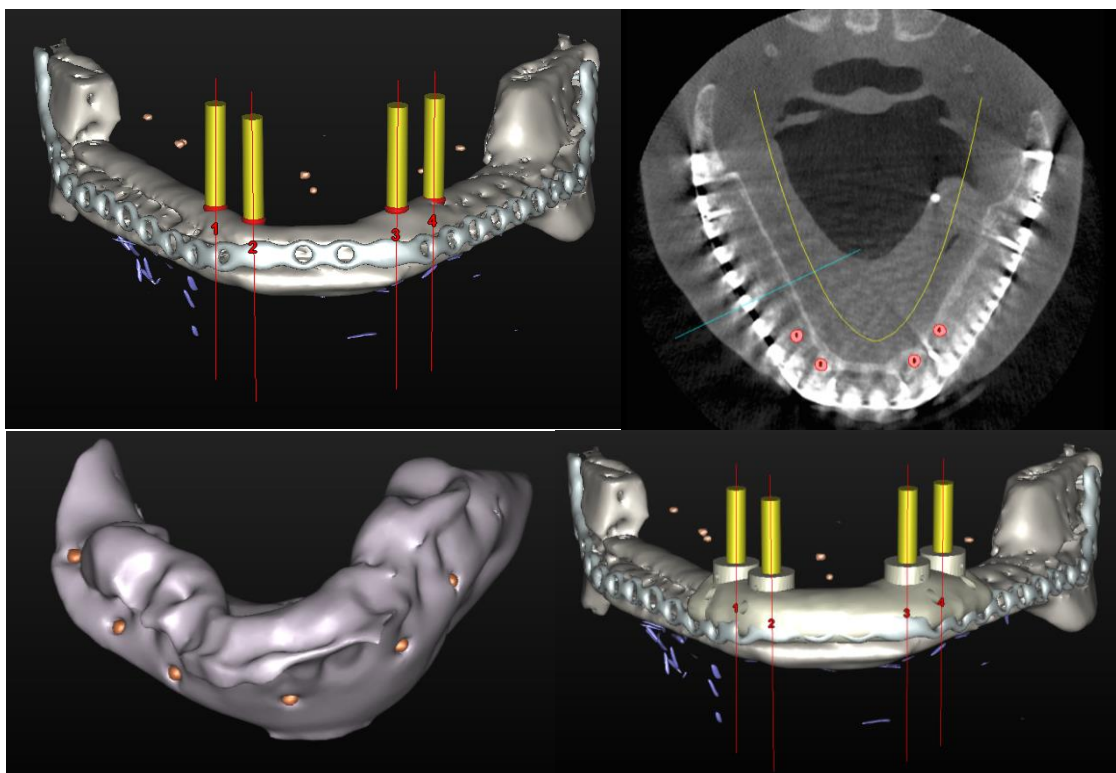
A patient with partial mandibulecomty and reconstruction with fibula free flap. A complete mandibular prosthesis was constructed to idealise tooth positioning. The prosthesis was copied and radiographic markers (Simplant Dual Scan Markers) placed and used as a radiographic stent. A polyvinylsiloxane bite record was so the stent can be accurately located during the CBCT. The CBCT shows markers (orange) to help guide implant placement from the scanned prosthesis.
